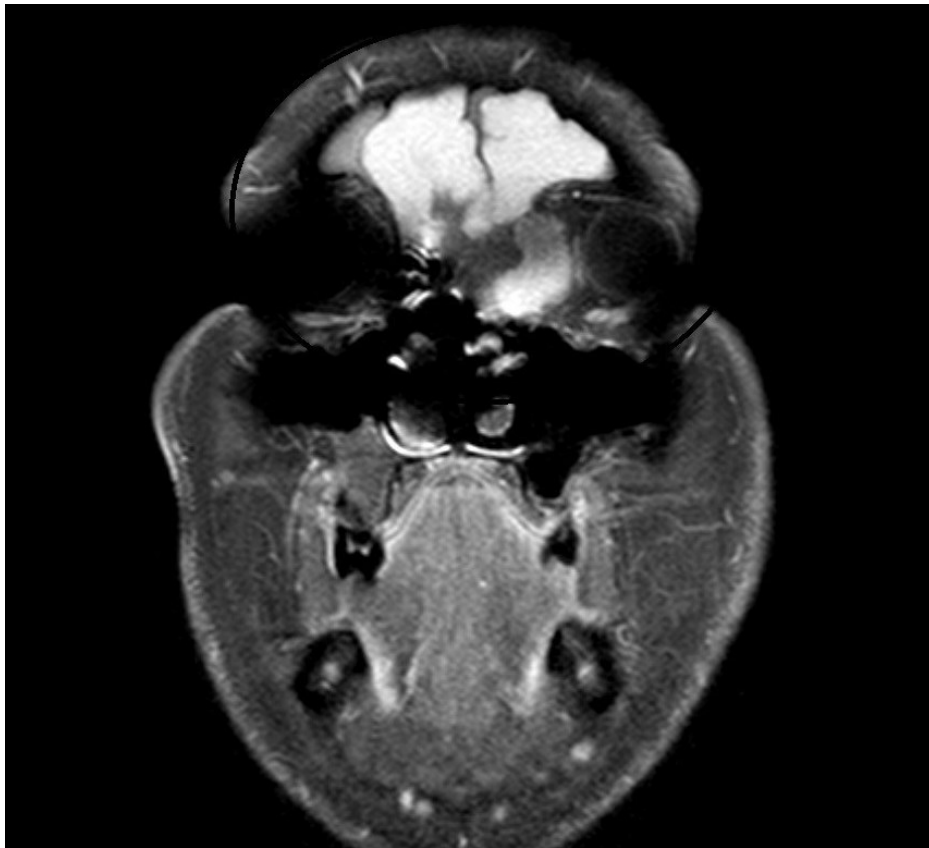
MRI image of bilateral frontal mucocele (T1 weighted coronal section)
